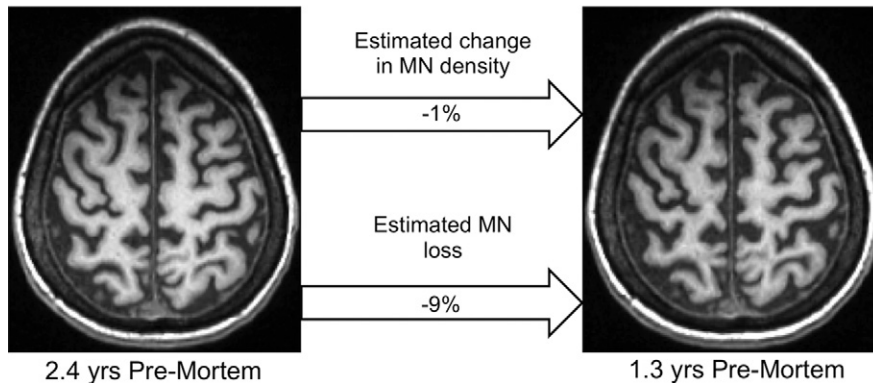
Monitoring change in MN density and MN loss in vivo. In vivo T1-weighted MR imaging from female patient with sporadic ALS with bulbar onset at 57 years old. The MR examinations were acquired at disease duration of 1.2 years and 2.3 years.
